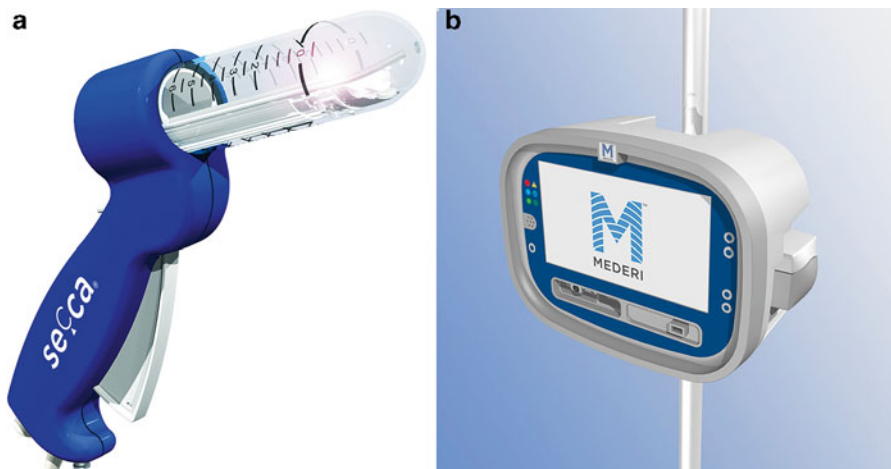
(a, b) Secca® Radiofrequency device (Courtesy of Mederi Therapeutics, Norwalk, CT; ©2014 Mederi Therapeutics, Inc.)
